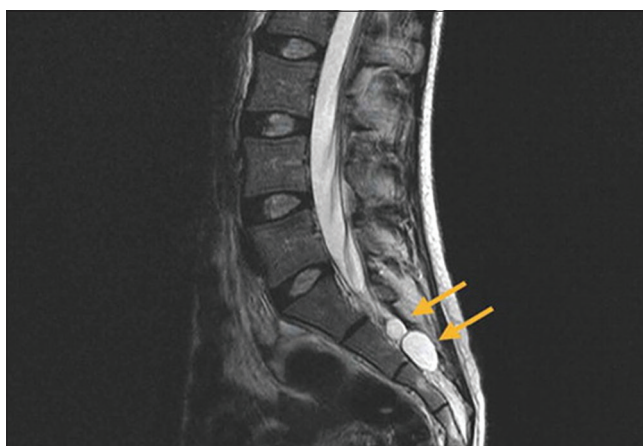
Sagittal T2-weighted magnetic resonance imaging of the lumbosacral spine revealing perineural (Tarlov) cysts (arrows) at the levels of S2 and S3.
